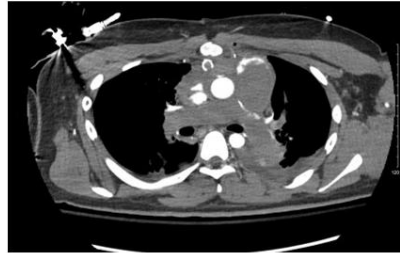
CT scan demonstrating PA thrombosis
